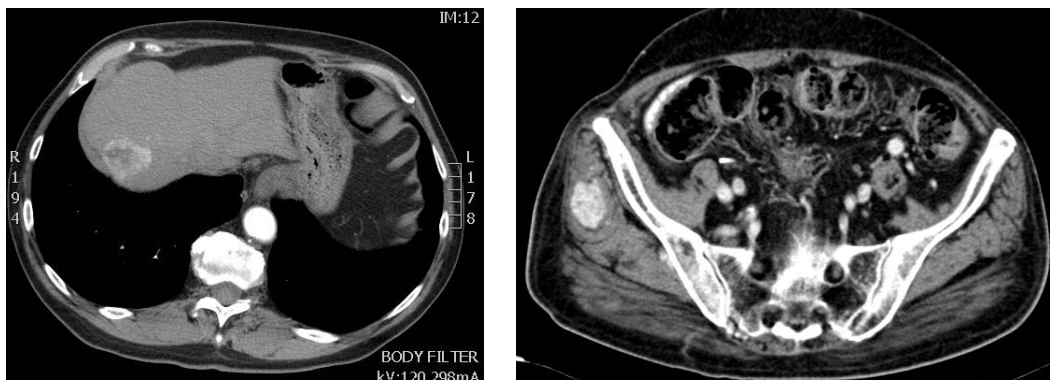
Contrast enhanced arterial phase CT of two patients with metastases from ccRCC. The liver metastasis at the left and soft tissue metastasis at the right display contrast enhancement due their high level of vascularization.
